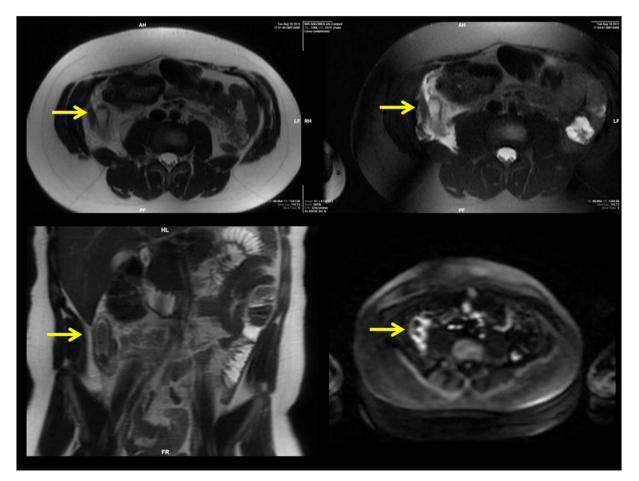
Key images from anonymized study showing uncomplicated appendicitis (arrow) in a 12-year old boy, including axial T2-weighted images with and without fat saturation, coronal T2-weighted image without fat-saturation, and axial Diffusion Weighted Imaging.
